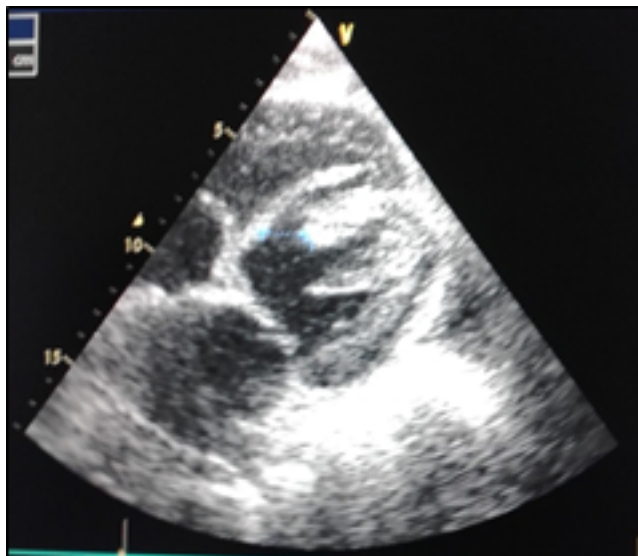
The echocardiographic aspect of the interventricular communication.
